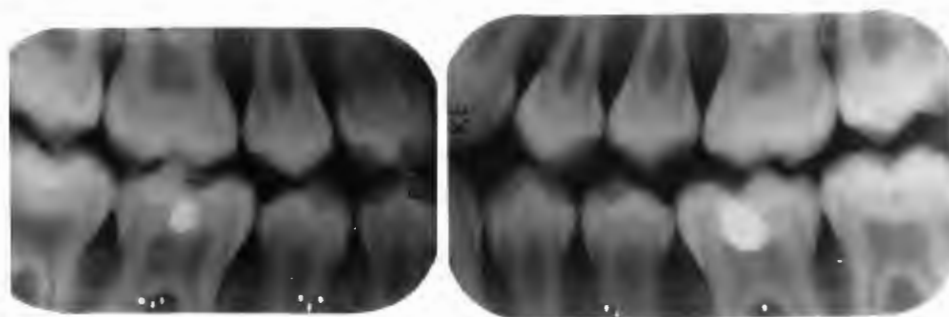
Bite-wing radiographs of a female (Case 5) with VDRR. The dental manifestations were of Grade II severity with moderate enlargement of the pulp chambers.
